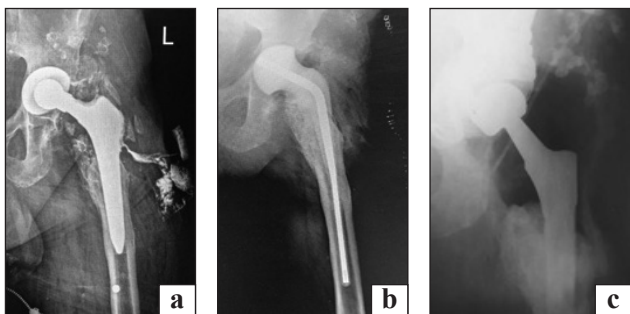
Patient Y. Radiographs "before" and "after" surgical interventions: periprosthetic infection of the left hip joint (a); after revision, installation of a metal-cement spacer (b); after revision arthroplasty (c)
